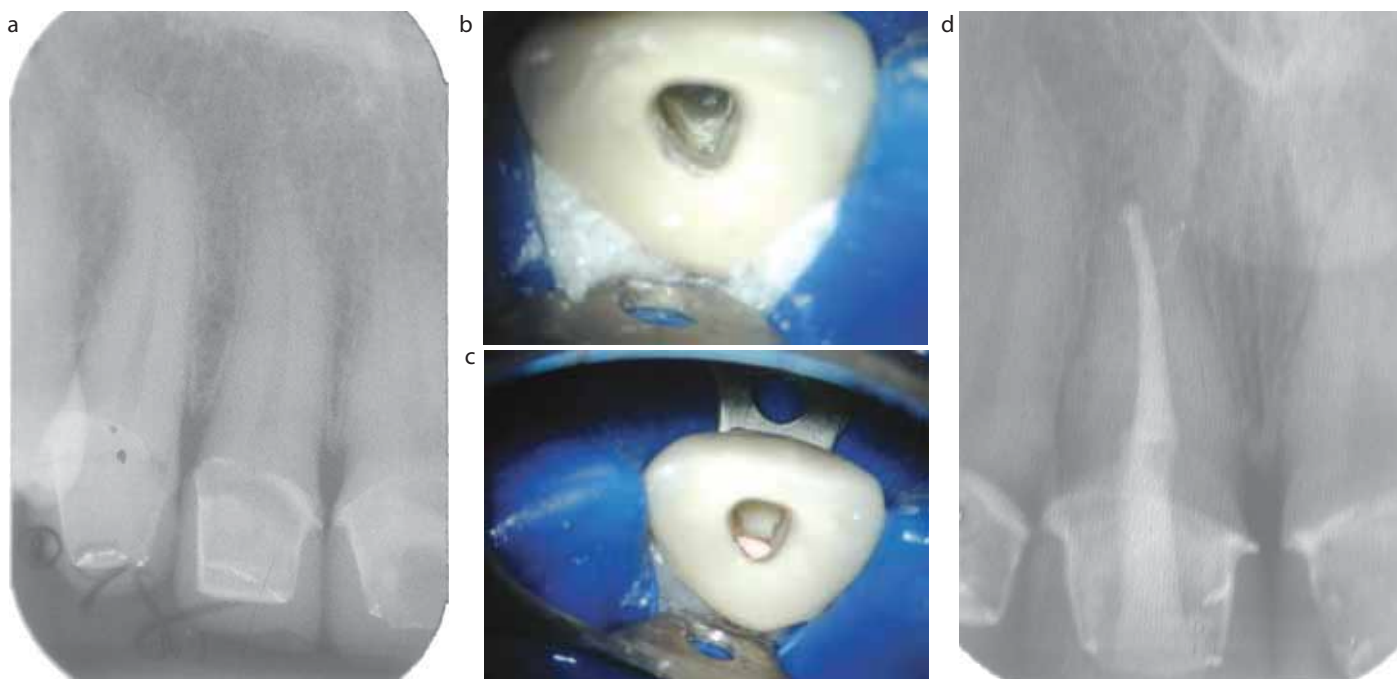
Case showing labial perforation: (a) pre-operative radiograph; (b) labial perforation; (c) glass-ionomer repair following placement of a barrier and (d) postoperative radiograph.
